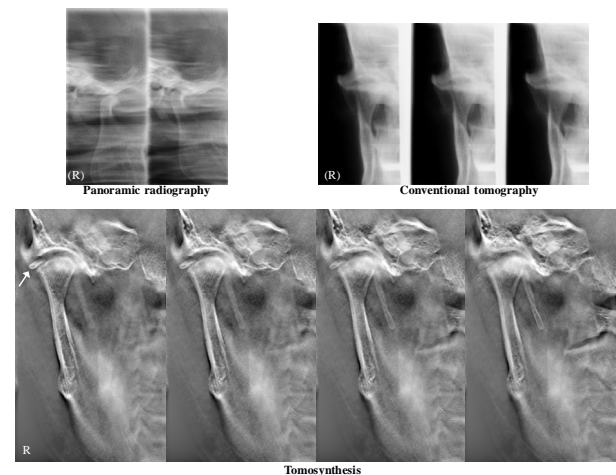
Patient (56-year-old woman; inflammatory disorder of the right temporomandibular joint). Panoramic radiograph (closed and open mouth) showing the mandibular condyle. Conventional tomography showing the right and left mandibular condyle. X-ray digital linear tomosynthesis images (different level positions) showing the mandibular condyle.
